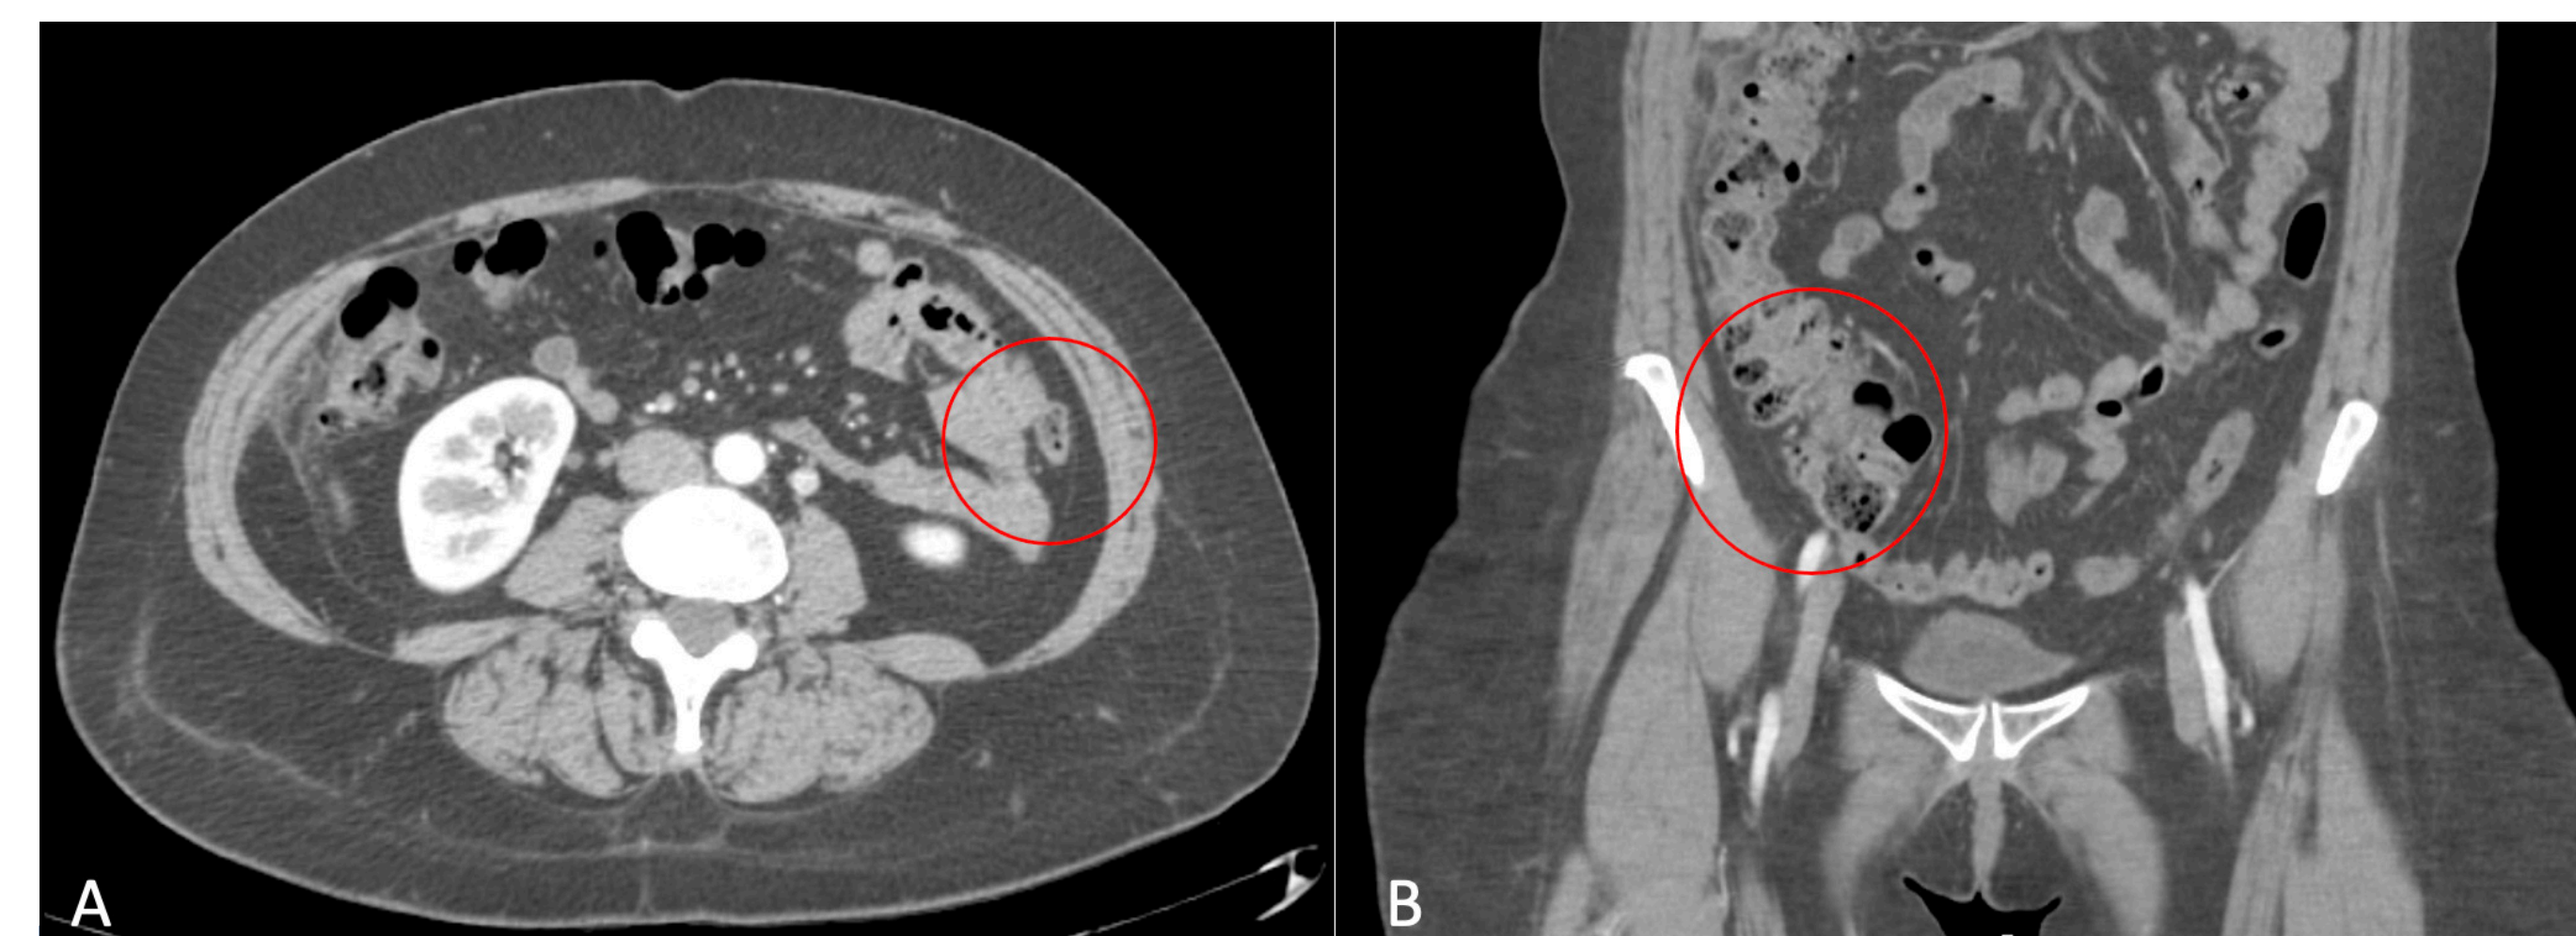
CT scan of abdomen pelvis with and without contrast
